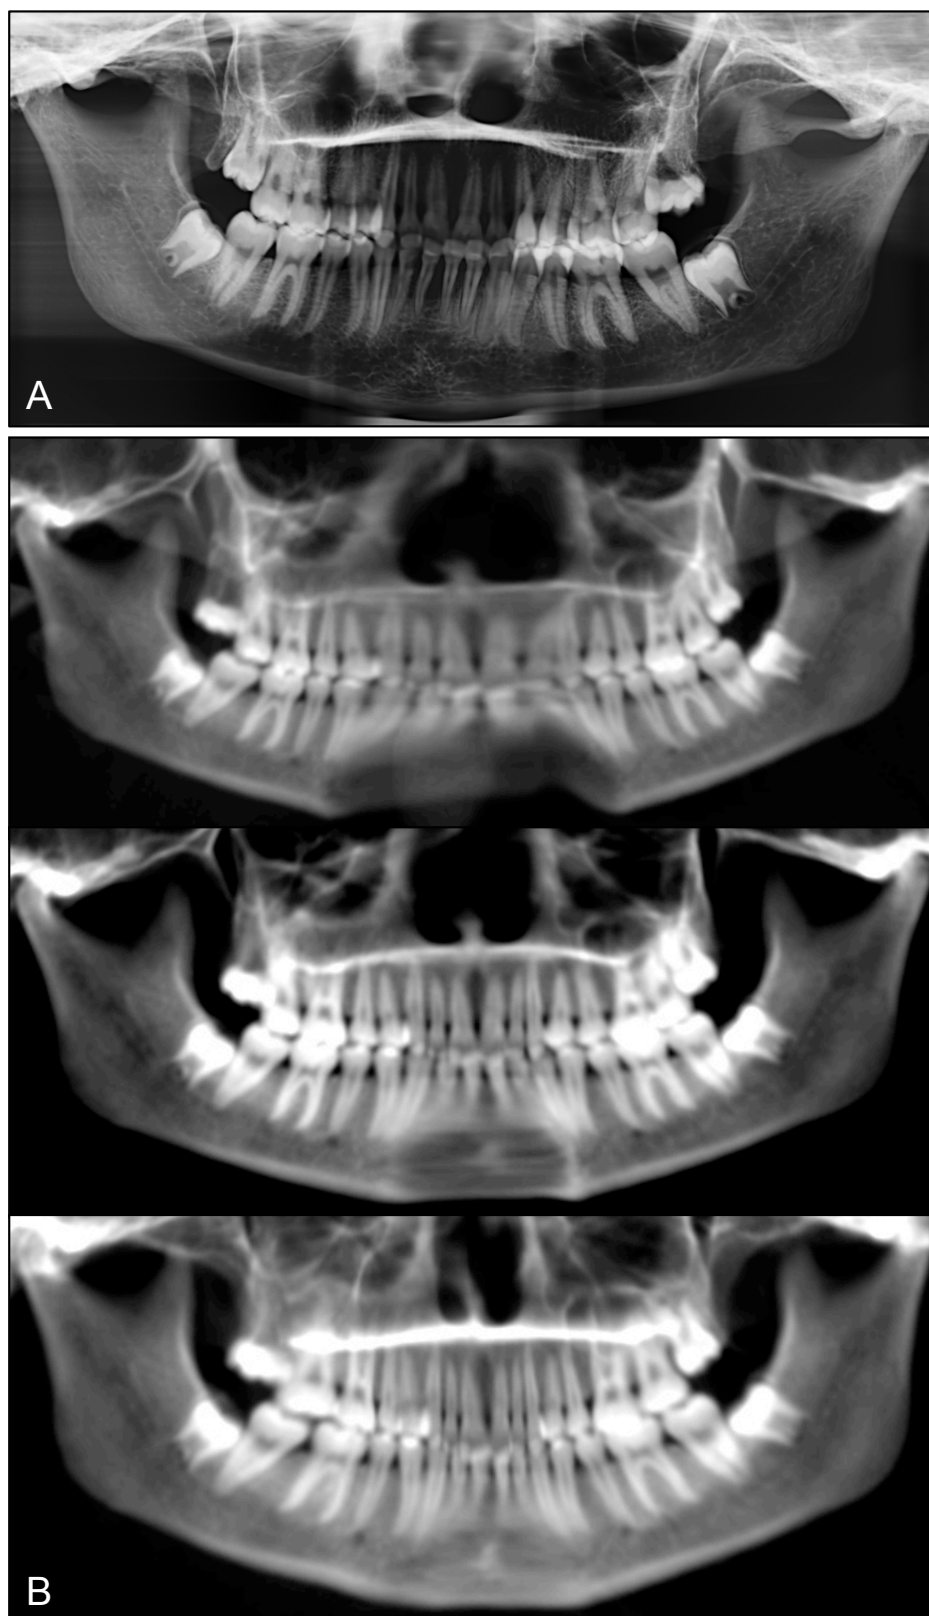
Traditional dental radiography Vs PMCT. A) Conventional Orthopantomograph (OPT) image B) Series of PMCT curved MPRs (Case 16, 18 years).
